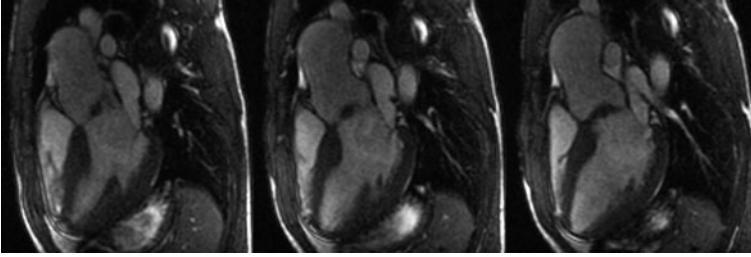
Cardiac MRI two-chamber views of the left atrium and left ventricle
